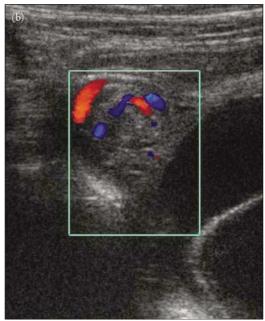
Whirlpool sign in ovarian torsion. The vascular pedicle of the ovary is twisted, forming this hypoechoic mass (arrows in Panel (a)). The bladder (BL) is above, while a cyst is seen, serving as a fulcrum for the ovary to twist. On color Doppler, there is a twisting of vascular flow (Panel (b)). Adapted from Figure 3 of Vijayaraghavan SB. Sonographic whirlpool sign in ovarian torsion. *J Ultrasound Med.* 2004;23:1643–1649.
